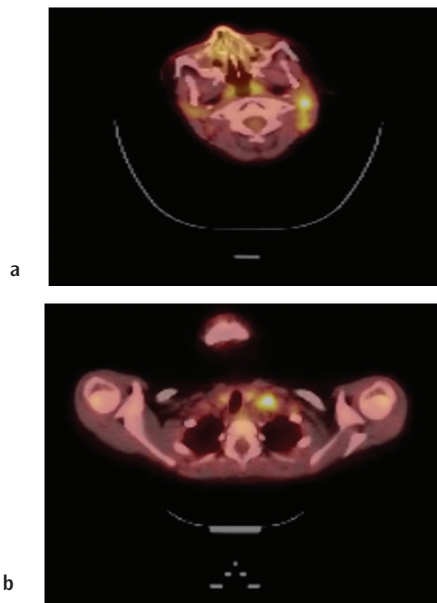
a,b) In the positron emission tomography/computed tomography report of our patient, mild hypermetabolic lymphadenopathy with conglomerate is observed on the left side of the neck (jugulo-digastric and supraclavicular lymph nodes)
